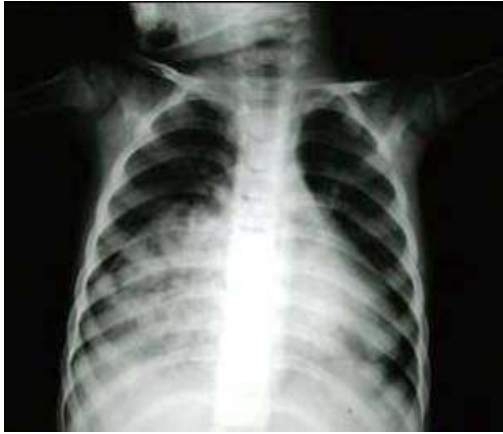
(a) Antero posterior and (b) lateral chest radiograph demonstrating retrosternal gas shadow. These findings were interpreted as anterior herniation of bowel loops.
